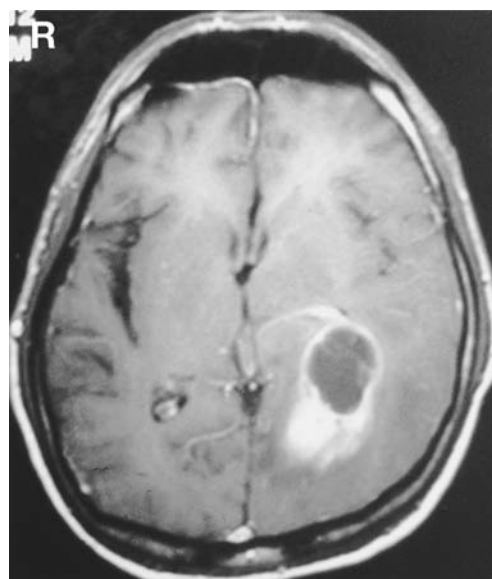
Axial T₁-weighted magnetic resonance image with contrast medium showing a non-homogeneously enhanced mass with a well-delineated cyst in the left parietal lobe.
